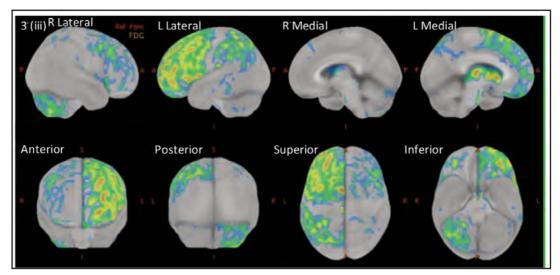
(iii) Subsequent FDG PET-CT shows asymmetrical pattern of FDG hypermetabolism involving both frontoparietal cortices, more on the left
